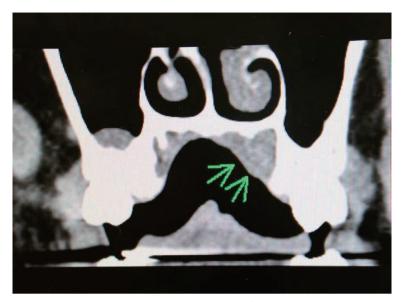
Computed tomography scan showing a hard palate lesion (arrows) without bone involvement (coronal view)
